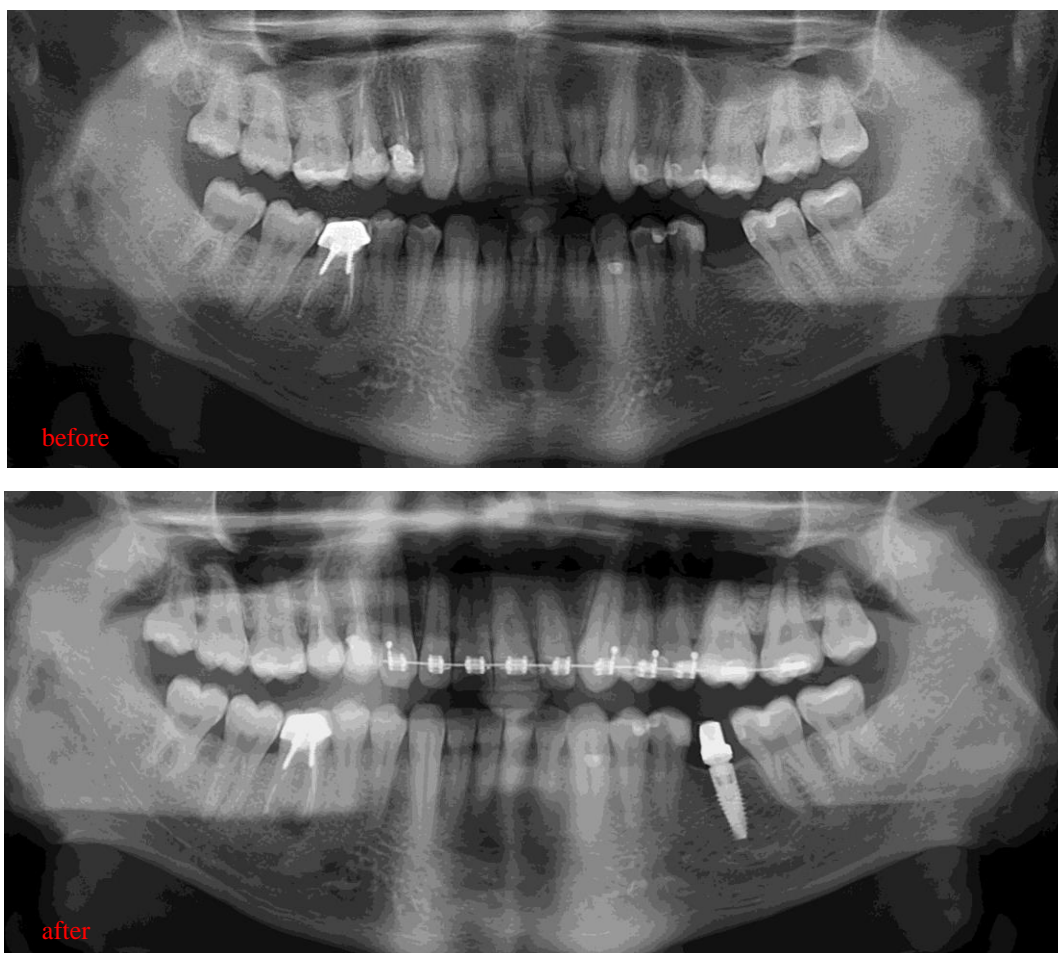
Panoramic radiographs before and after implant insertion surgery. On the panoramic radiograph performed after surgery, it can be seen that the implant is in an ideal position, at the middle of the distance between the neighboring teeth.
